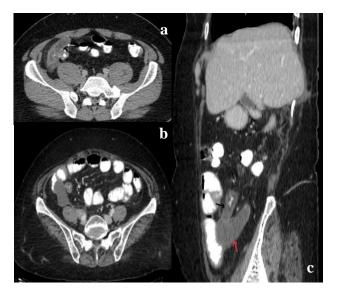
Case 3- axial unenhanced (a) and contrastenhanced; and (b) CT scan images show lowattenuation tubular mass (red arrows) contiguous with base of cecum, along with thickened terminal ileum. Sagittal contrast enhanced (c) CT scan image shows relation of base of cecum and lesion.
